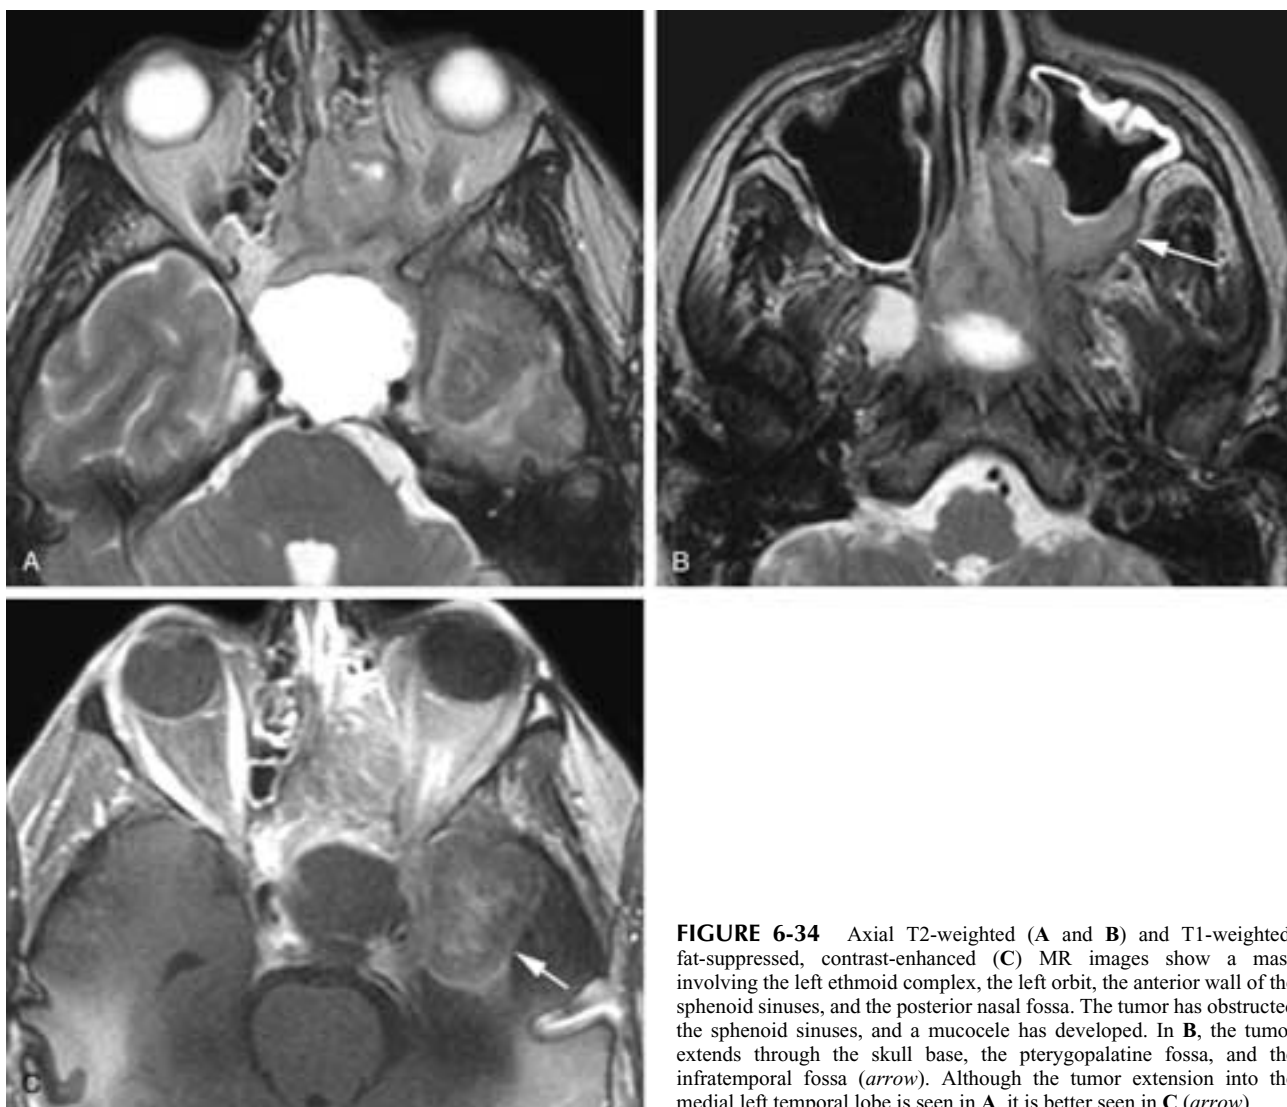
Axial T2-weighted (A and B) and T1-weighted, fat-suppressed, contrast-enhanced (C) MR images show a mass involving the left ethmoid complex, the left orbit, the anterior wall of the sphenoid sinuses, and the posterior nasal fossa. The tumor has obstructed the sphenoid sinuses, and a mucocoele has developed. In B, the tumor extends through the skull base, the pterygopalatine fossa, and the infratemporal fossa (*arrow*). Although the tumor extension into the medial left temporal lobe is seen in A, it is better seen in C (*arrow*).
